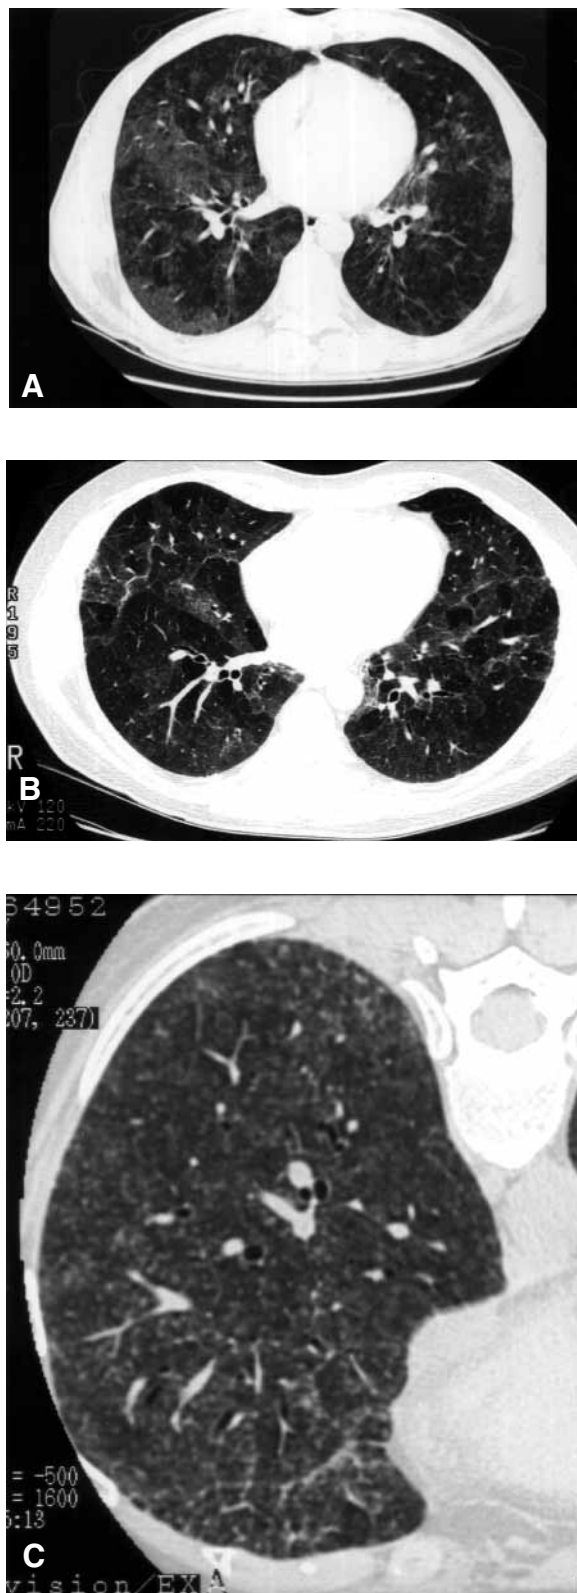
HRCT of the chest. A, Patient with HP has patchy ground-glass opacities. B, Patient with HP has patchy ground-glass opacities with areas of air trapping (*dark areas*) in a mosaic pattern (expiratory view). C, Patient with HP has diffuse micronodular infiltrates.
